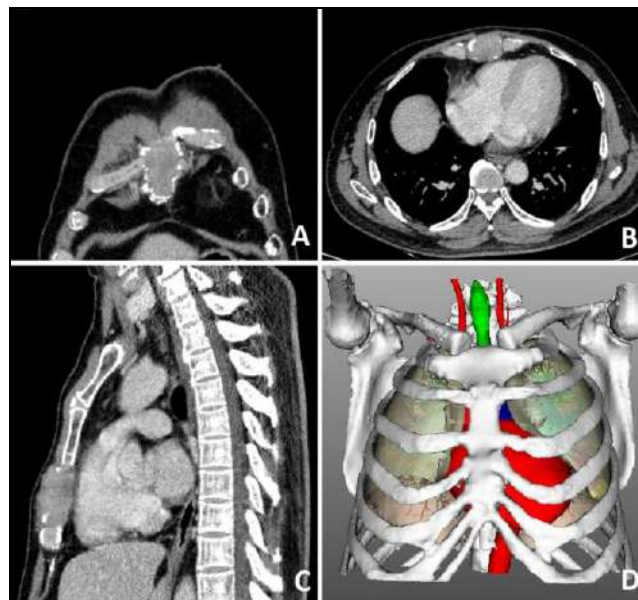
Preoperative imaging examination. A. CT coronal plane; B. CT horizontal plan; C. CT sagittal plane; D. 3D reconstruction.
